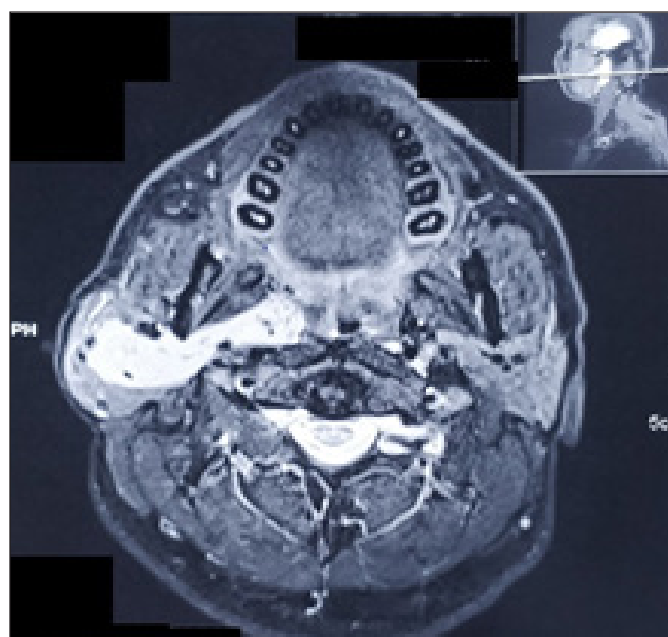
Preoperative MRI imaging of the lesion in axial incisions showing a hyperintense lesion.
